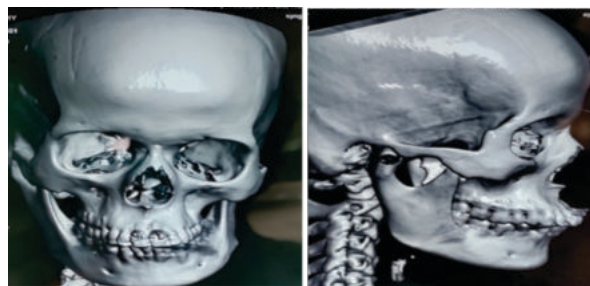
preoperative 3D CT scan
